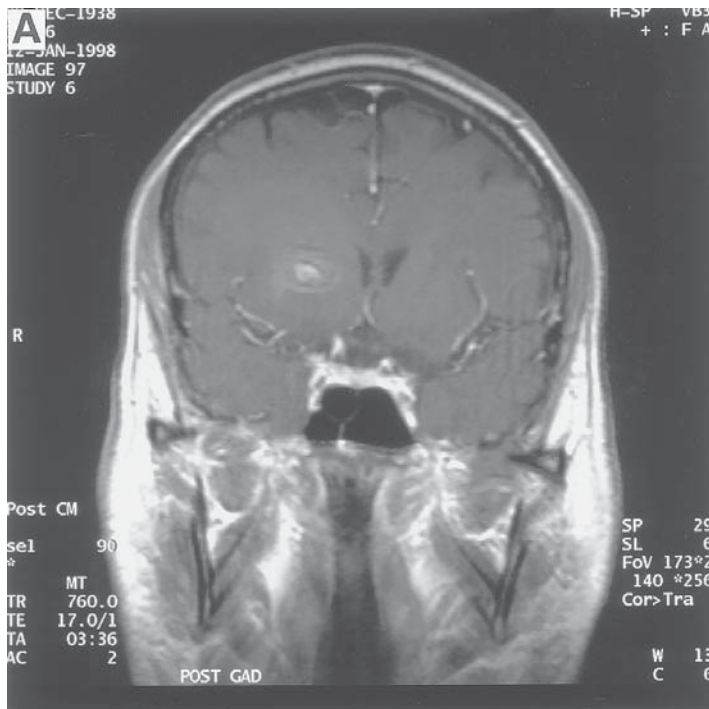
(A) Pretreatment MRI scan of a 59-yr-old man with RCC metastatic to the right internal capsule.
